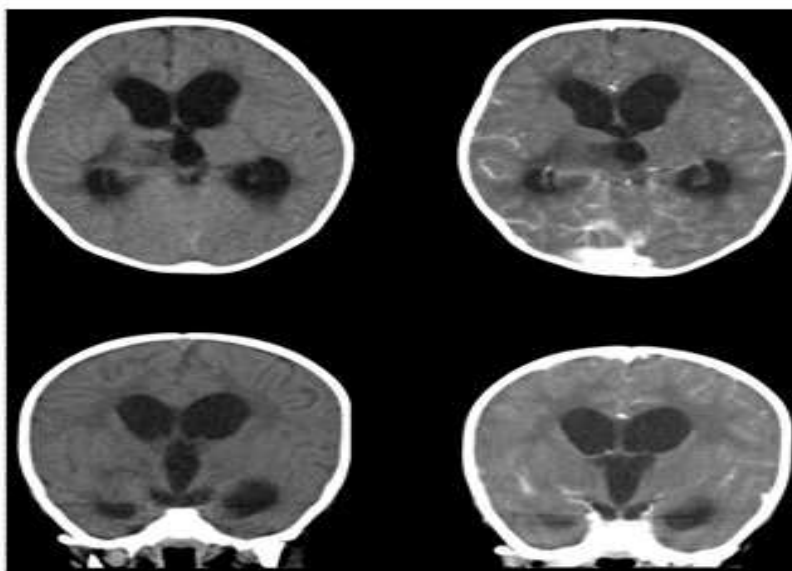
CT scan brain showing low attenuated areas and increase enhancements with hydrocephalus in patient with pneumococcal meningitis
